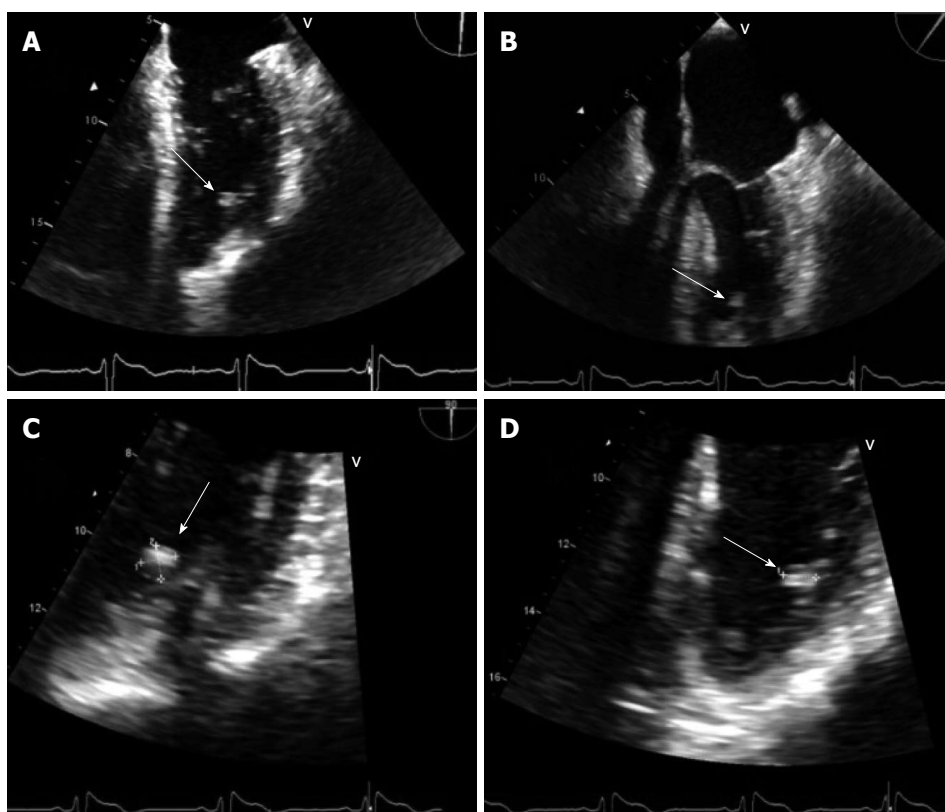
Transesophageal echocardiogram. A: Mid esophagus view of the transesophageal echo (TEE) revealing left ventricular myxoma; B: TEE, four chamber view showing Left ventricular myxoma; C: Magnified view showing a myxoma, size 1 cm x 2 cm; D: Magnified view showing a myxoma of 1 cm in horizontal direction. Showing its close proximity to trabecular muscles.
